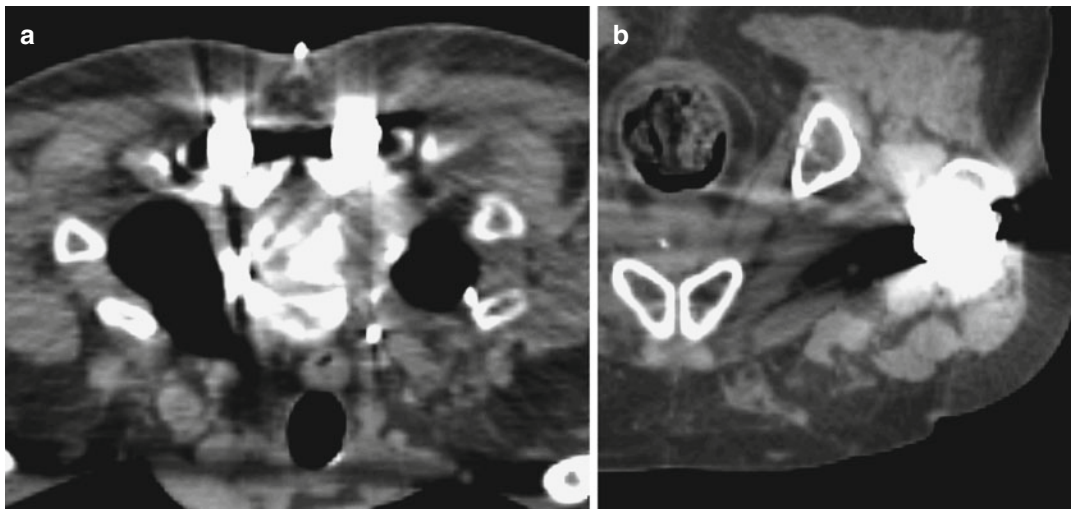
(a) An example CT slice at the level of the thorax for a patient with stabilizing metal (titanium) implants and (b) in the pelvis for a patient with a hip prosthesis
